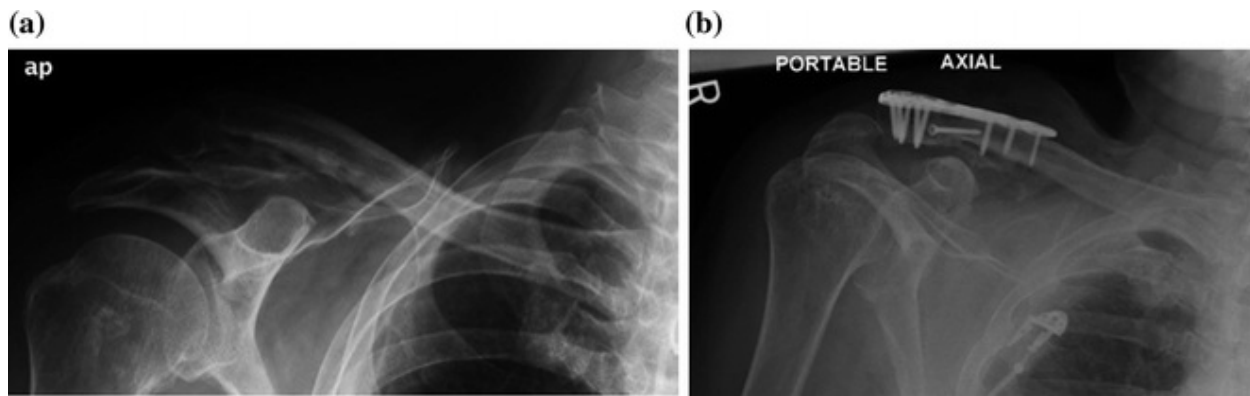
a Preoperative radiograph of distal clavicle nonunion. b Post-operative radiograph of distal clavicle nonunion following open reduction and internal fixation with a precontoured distal clavicle plate and a lag screw
